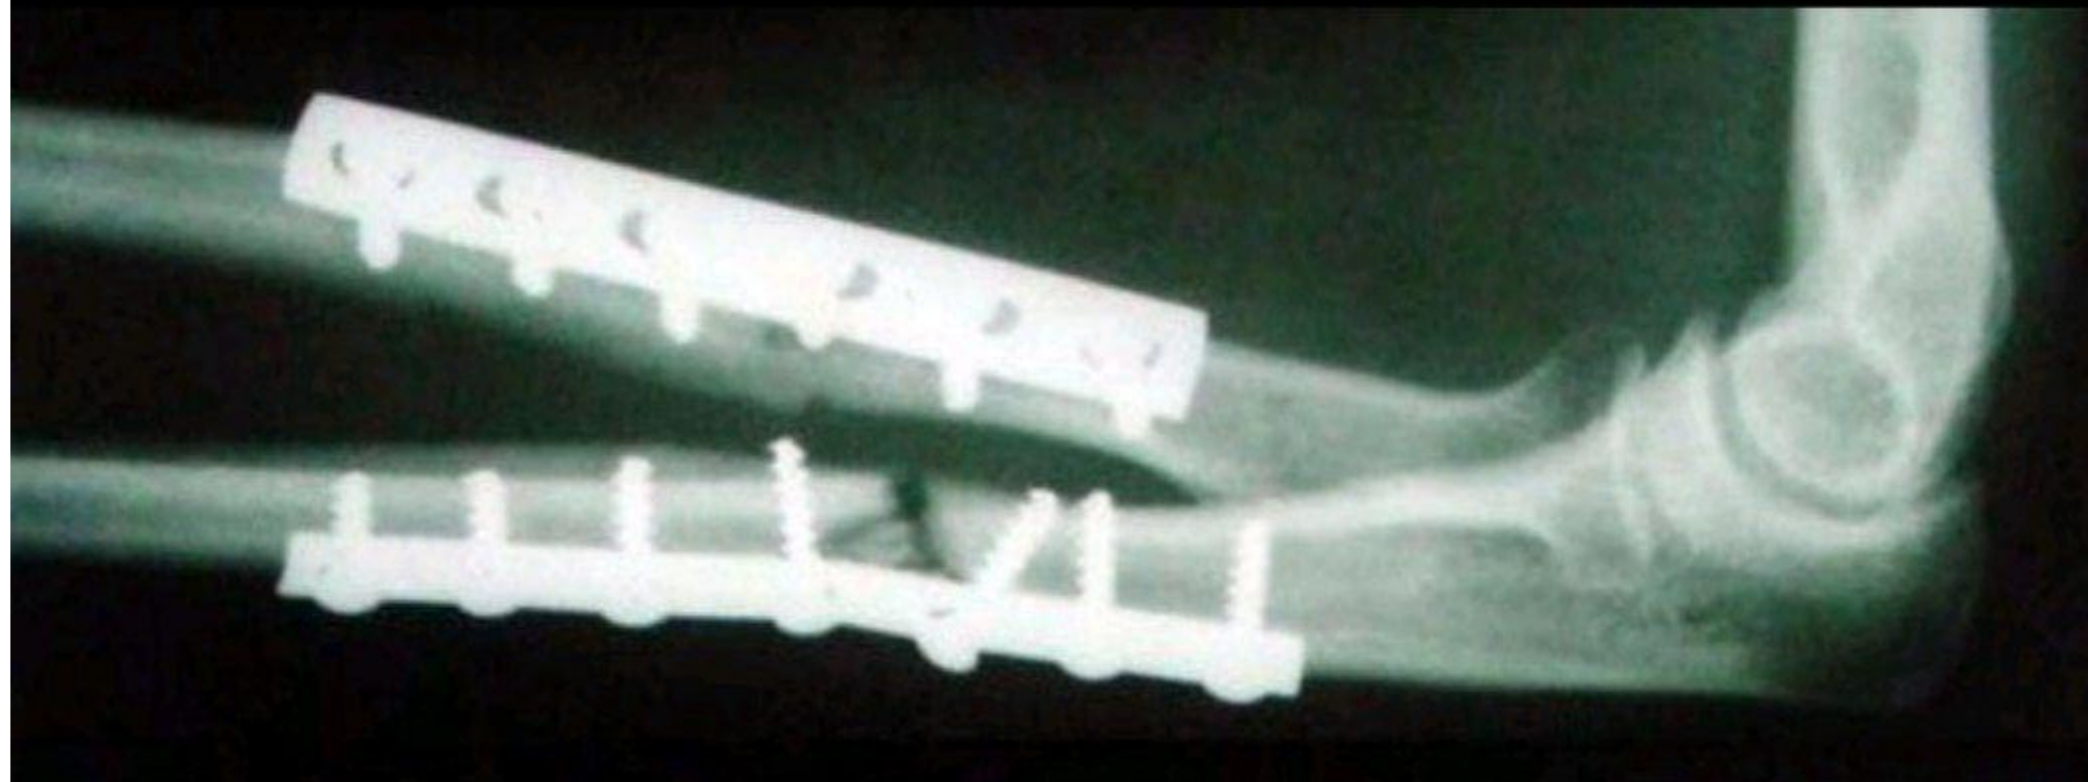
Figure A is the radiograph of a 52-year-old male who underwent open reduction and internal fixation (ORIF) of a both bone forearm fracture six months prior. He complains of persistent pain at the ulna fracture site. His C-reactive protein and erythrocyte sedimentation rate are within normal limits. What is the most appropriate definitive treatment for this patient?
